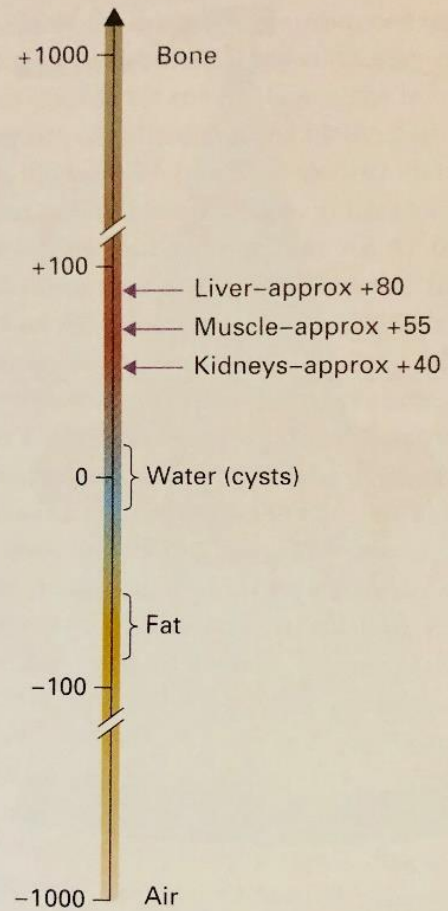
Scale depicting the CT density (Hounsfield units) of various normal tissues in the body.
